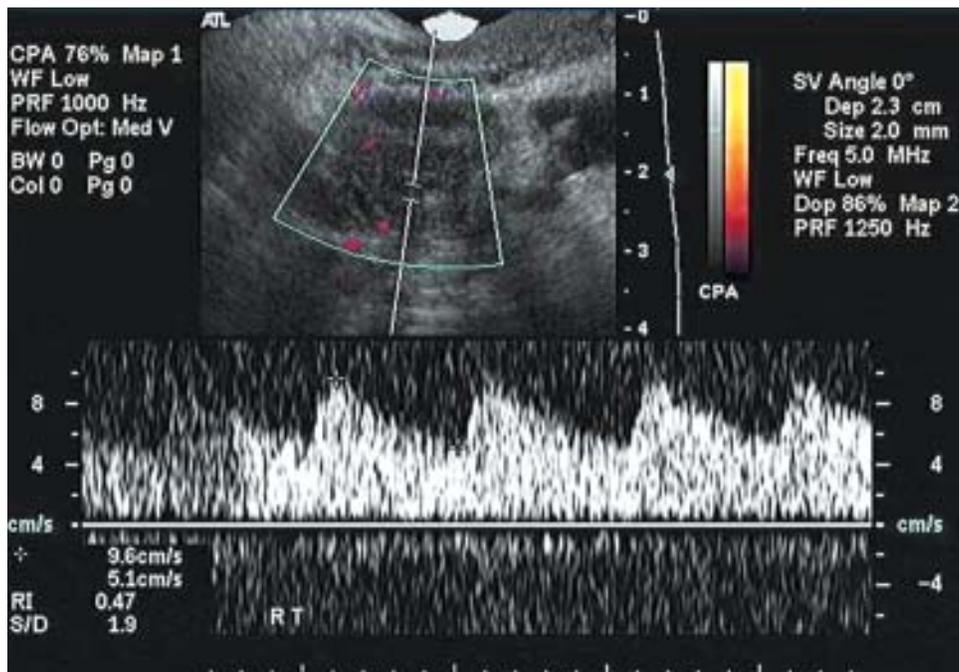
Pulsed Doppler waveform analysis of the luteal blood flow. Note the low resistance to blood flow
